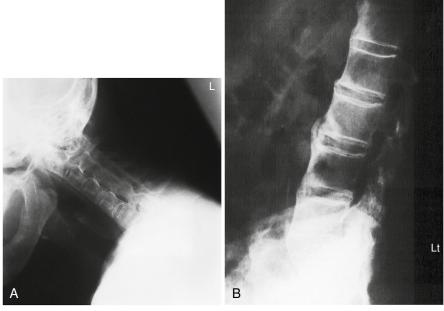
A, Lateral cervical spine radiograph depicting ankylosing spondylitis with granulation tissue beneath the anterior longitudinal ligament destroying the corners of the contiguous vertebra. B, Lateral lumbar spine radiograph of a 64-year-old man with ankylosing spondylitis. Note the fusion of the vertebrae into a solid block of bone. (From American College of Radiology, Reston, Virginia.)
